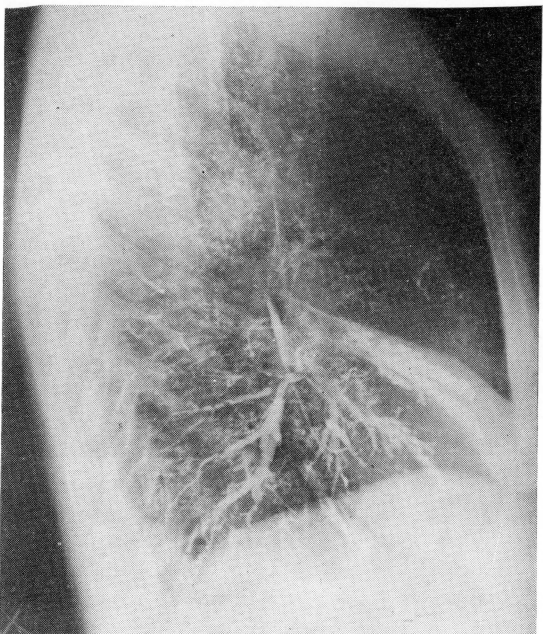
"Radiographic" bronchiectasis in the middle lobe. This, as bronchiectasis elsewhere, is reversible in the early stages
